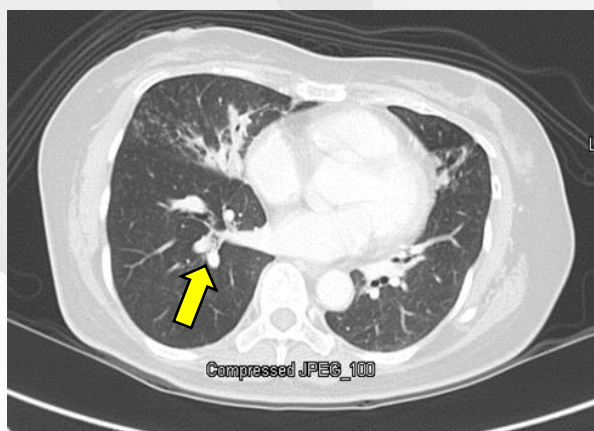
High-resolution CT (2011) showing bronchiectatic changes and tree-in-bud opacities (arrow) in the right middle lobe.
